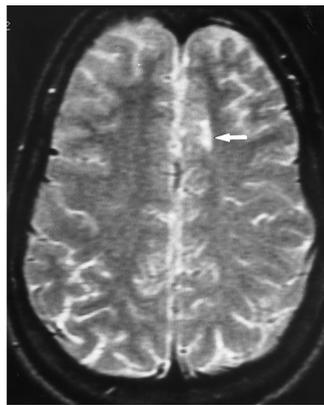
Signal extension to the ventricle by balloon cell FCDT. Sagittal proton density-weighted image (1500/30/1) (A) shows a hyperintense subcortical white matter lesion with hyperintense signal extension to the ventricle. The signal tapers as it extends to the lateral ventricle. B-E are sequential axial T2-weighted (1700/80/2) images extending inferiorly toward the lateral ventricles of the same lesion. It is difficult to determine whether the subcortical hyperintensity (arrows) extends to the ventricle when viewed in planes orthogonal to the signal extension.
